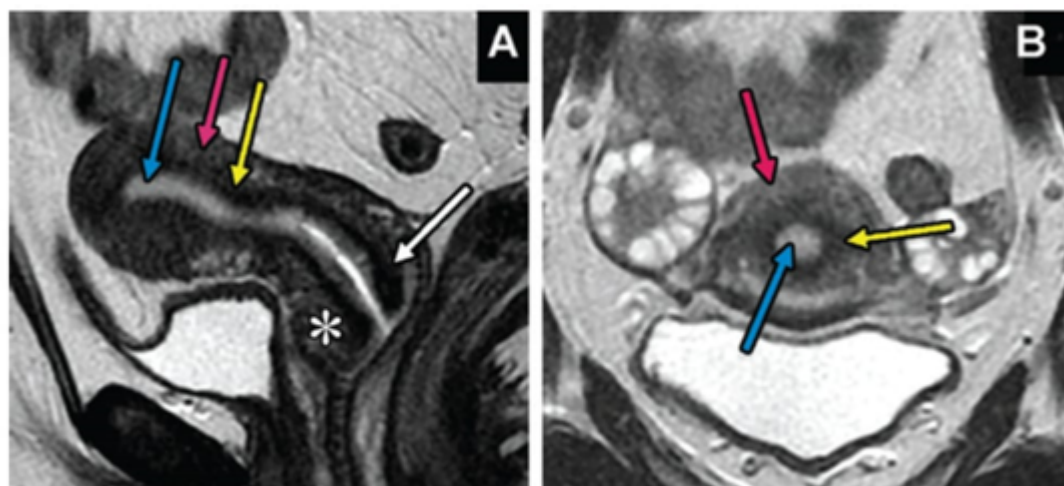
Normal anatomy of endometrium myometrium and junctional zone on MRI
